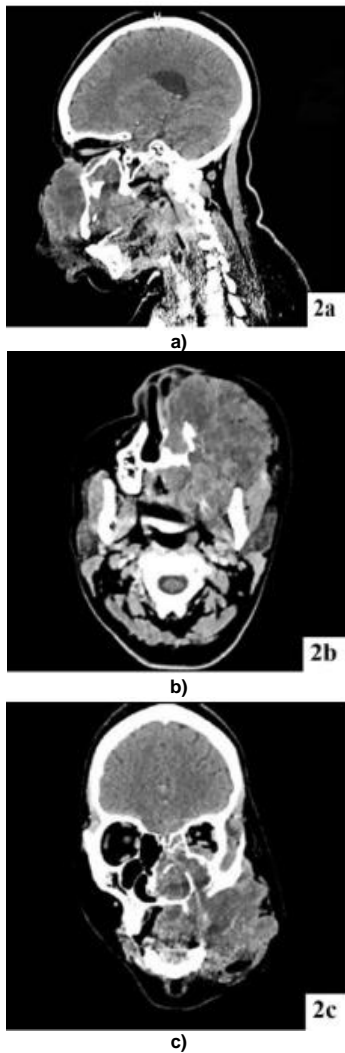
Selected computed tomography (CT) scan of the maxillary lesion (a) sagittal view, (b) axial view, and (c) coronal view. The CT scan demonstrates a heterogeneous soft tissue mass, originating from the left maxilla, involving the left paranasal sinuses and the orbital floor destroying the facial bones.
